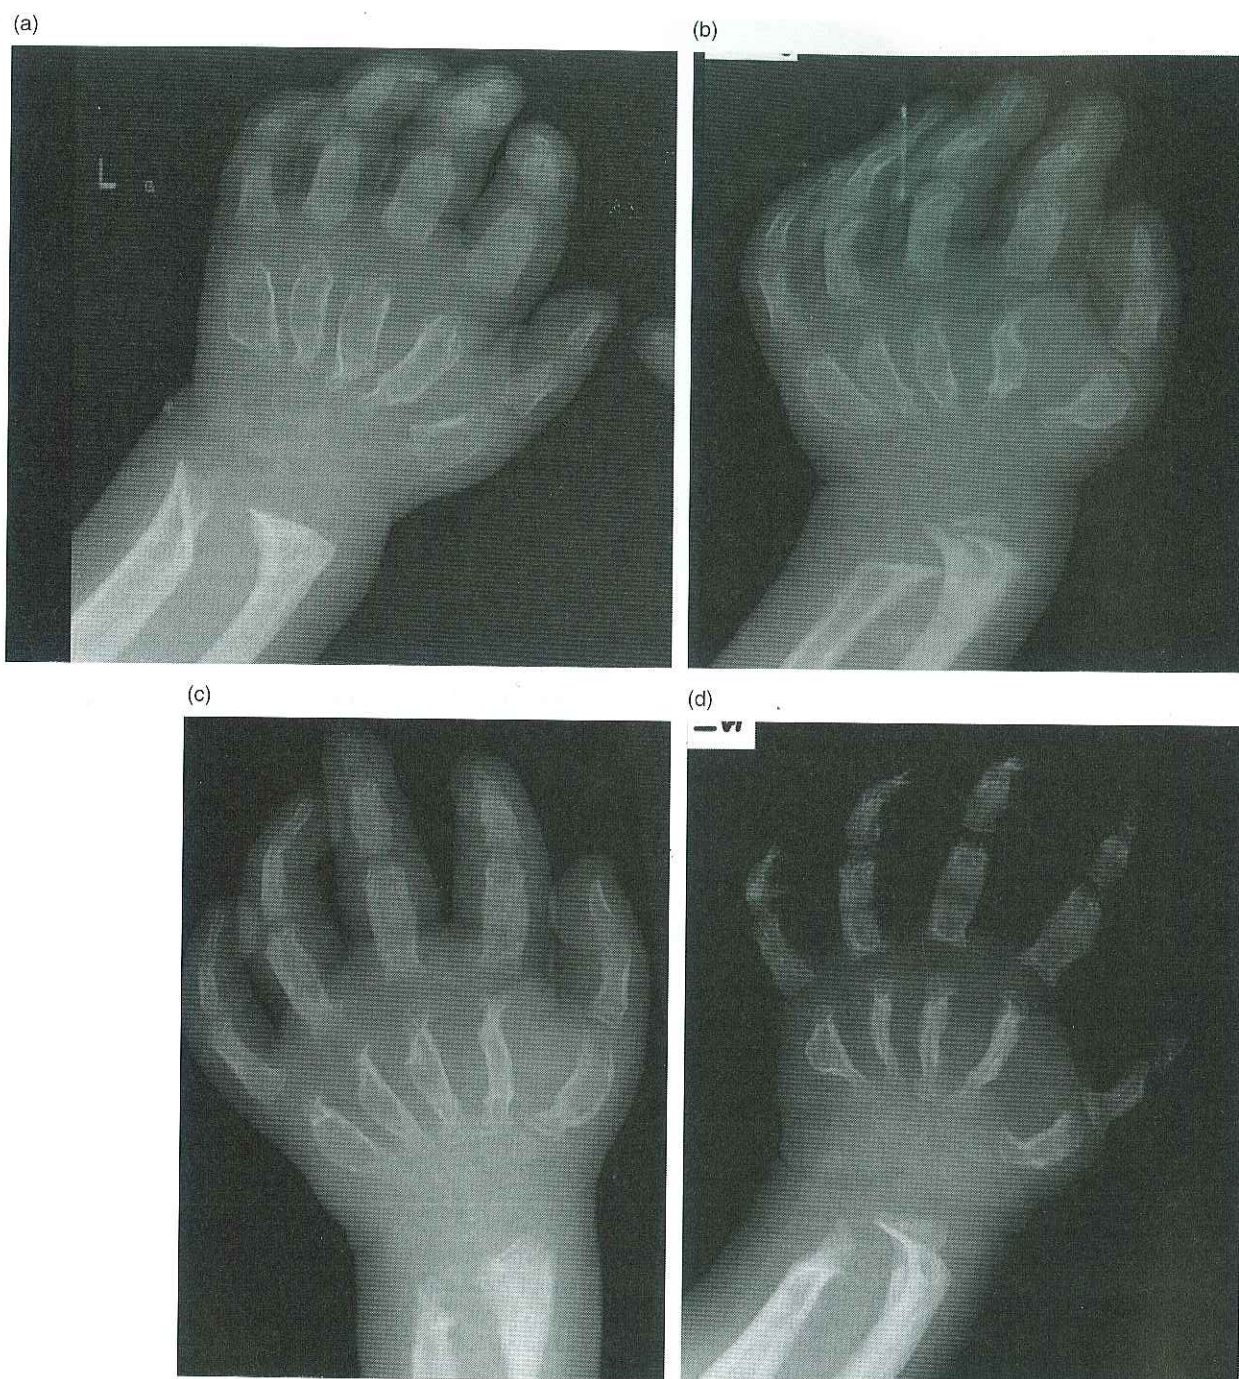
Radiograph of hands and wrists in four individuals affected with ML intermediate aged (a) 4 years, (b) 16 years, (c) 18 years and (d) 19 years showing progressive osteolysis of carpal centres, proximal metacarpals and distal forearm bones. ML, mucopolidosis.
